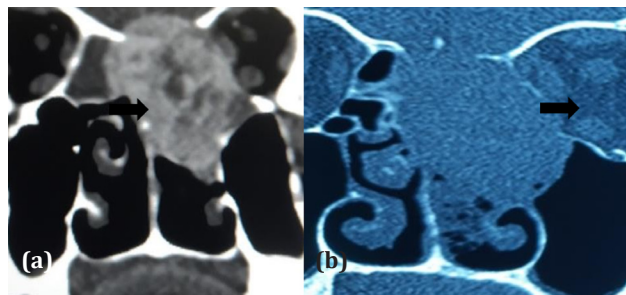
CT scan coronal section shows a well-defined heterogenous lesion in the left nasal cavity with extension into the anterior cranial fossa superiorly, medial wall of left the orbit and maxillary sinus laterally and pushing the septum to the opposite side.
